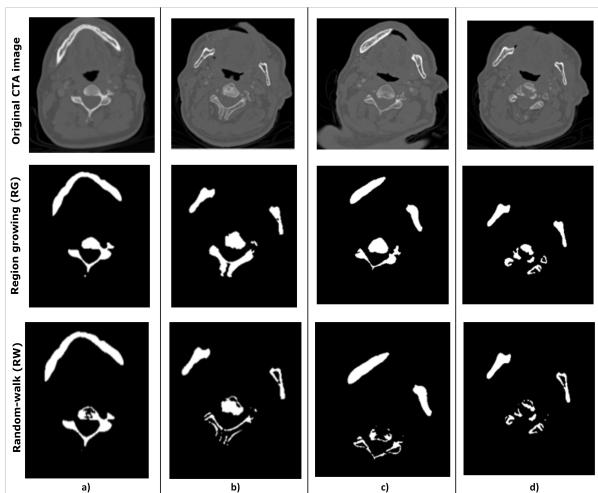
Comparing RG and RW bone segmentation at same seed points on four different CTA images.
